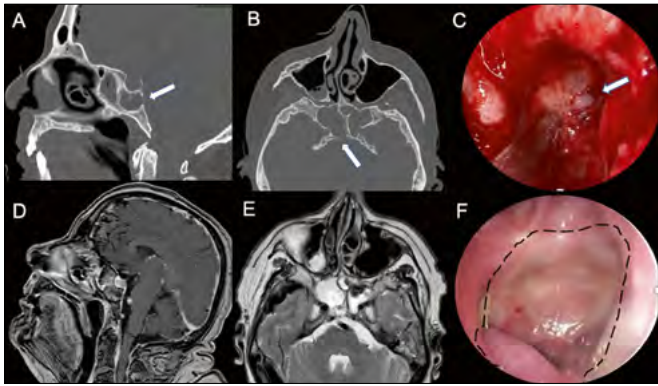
CT scan in sagittal (A) and axial view (B) in a case of meningoencephalitis (showed in the Sagittal post Contrast Enhancement MRI (D) and T2 weighted MRI (E) The bony erosion on the clivus as it appear endoscopically (arrow) The lesion was treated with multilayer technique and finally nasoseptal flap was used (dotted line in F) as it appear 2 months after surgery.
